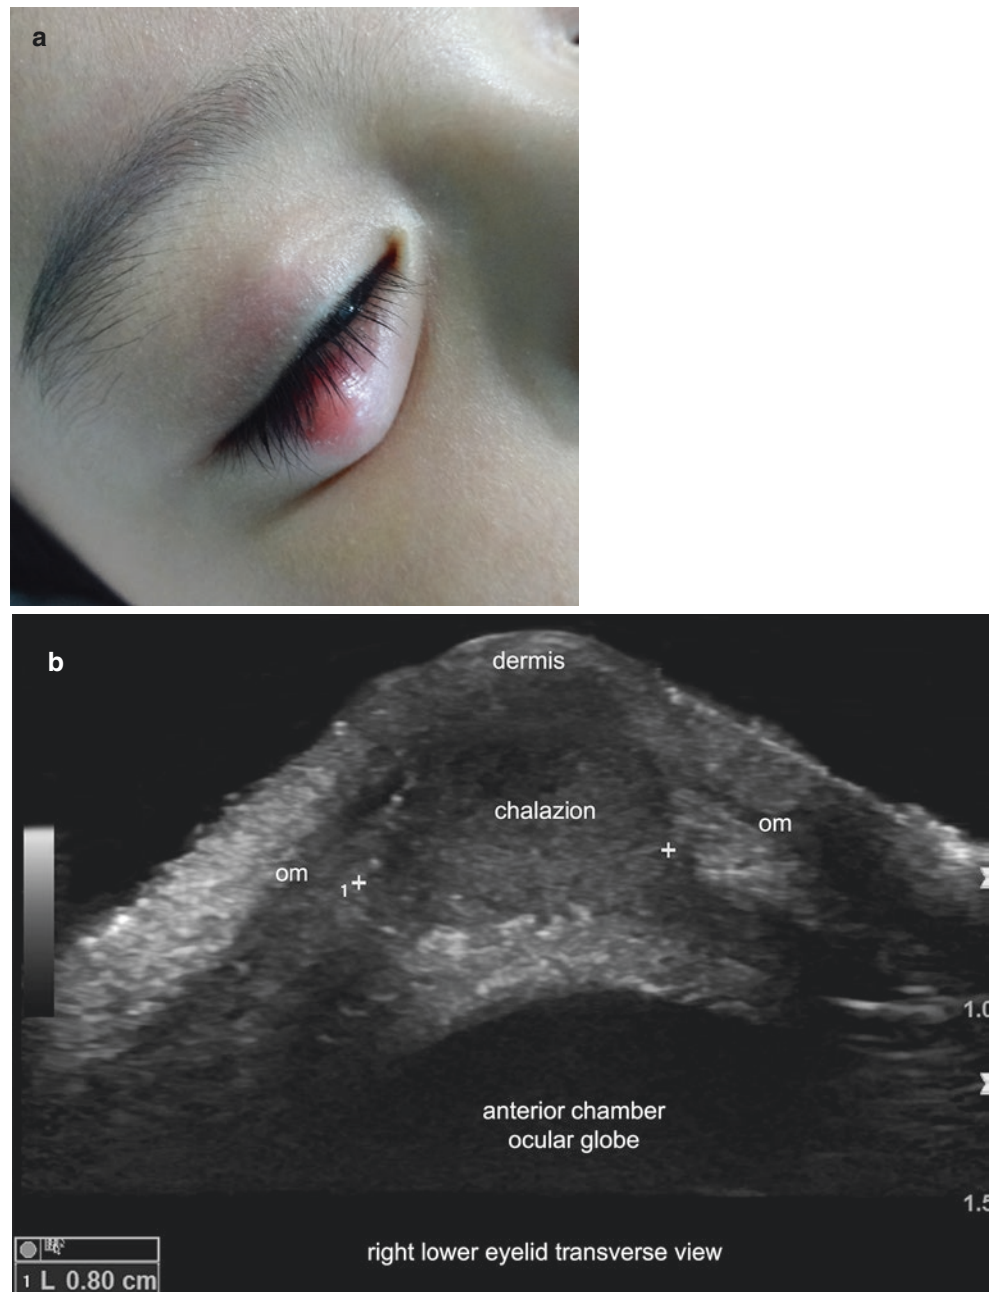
Chalazion. (a) Clinical image of the lesion at the right lower eyelid. (b) Ultrasound (greyscale, transverse view) shows a round, hypoechoic structure at the posterior aspect of the eyelid that extrinsically compresses the orbicularis muscle (om), which is displaced superficially. There is decreased echogenicity of the dermis. (c) Color Doppler demonstrates increased vascularity predominantly in the periphery of the structure. See Video 3.5.
